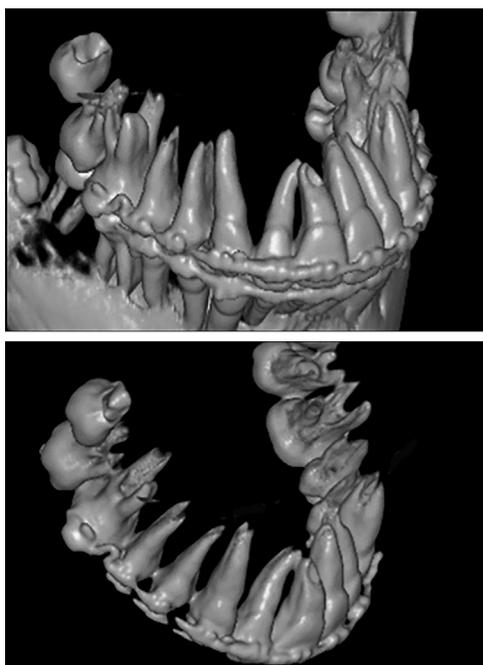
CBCT shows the overlap of the root apex of the maxillary right central and lateral incisors and the root resorption at the labial surface of the root of the maxillary right central incisor.
